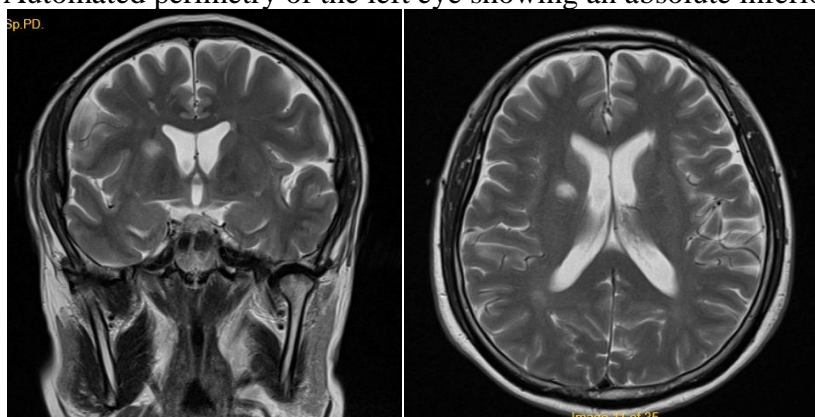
Contrast-enhanced brain MRI showed an infarction in the right corona radiata
